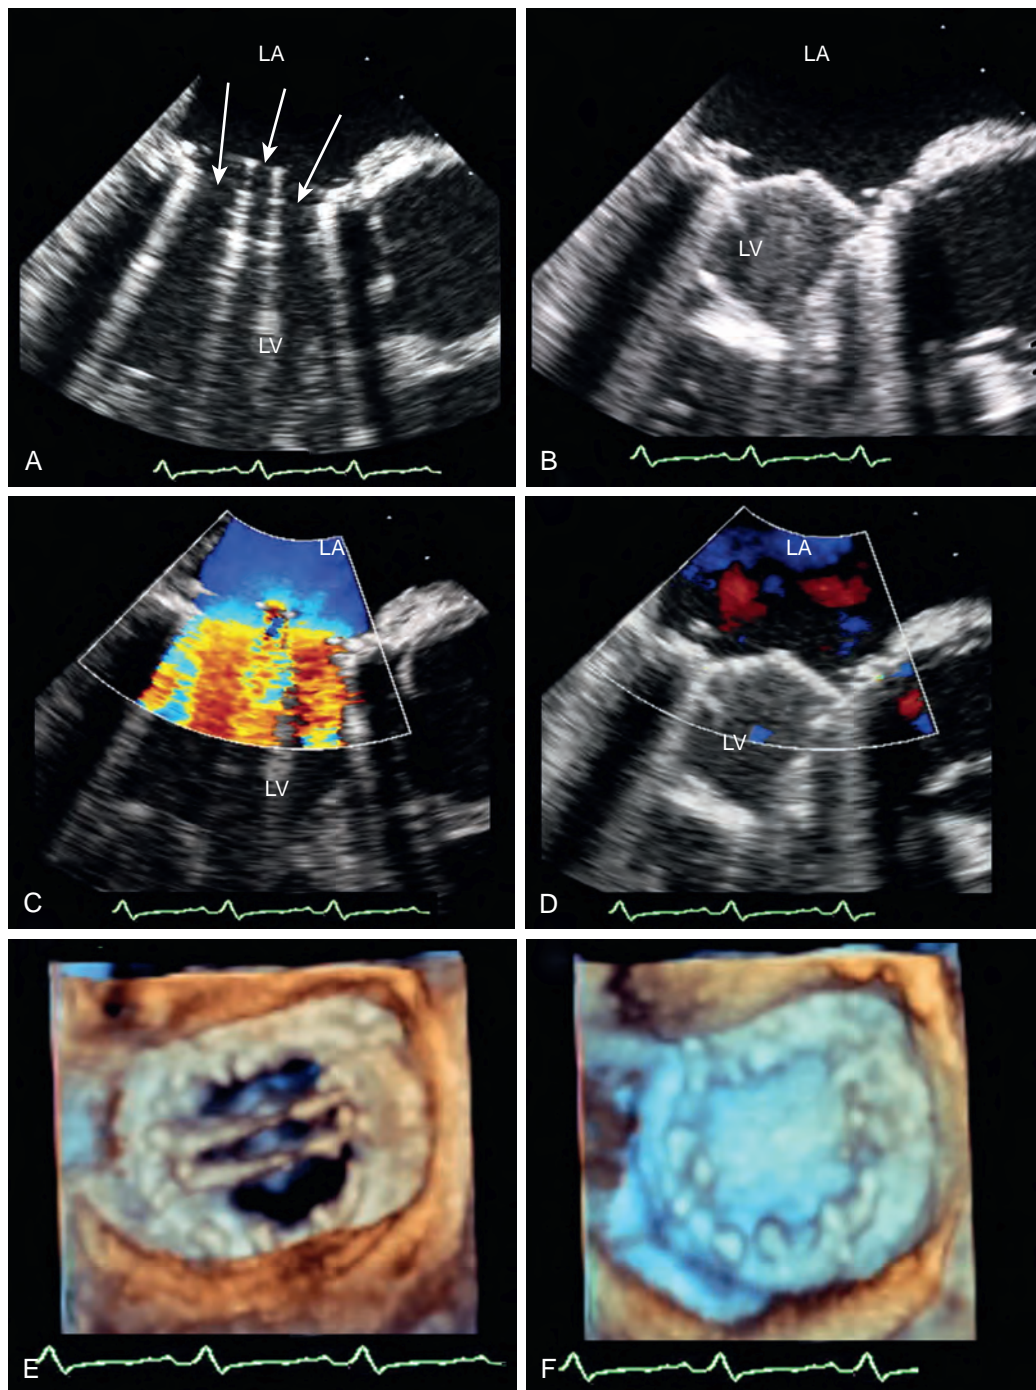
Normal mechanical mitral valve. Multiple images of the bileaflet mechanical valve during diastole (A, C, and E) and systole (B, D, and F) using two-dimensional imaging (*top*), color Doppler imaging (*middle*), and three-dimensional imaging (*lower*), the latter from left atrial perspectives. The arrows in (A) point to the three orifices during diastole. LA, Left atrium; LV, left ventricle.
